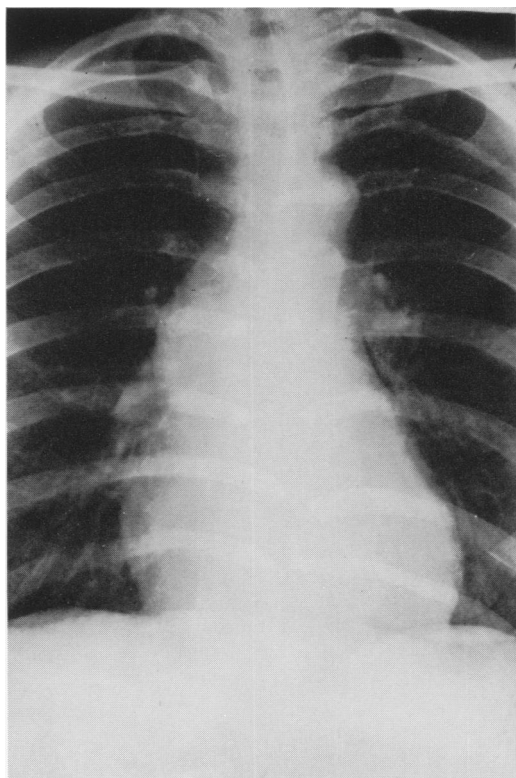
Roentgenogram of the chest demonstrating the dilatation of the ascending aorta.
